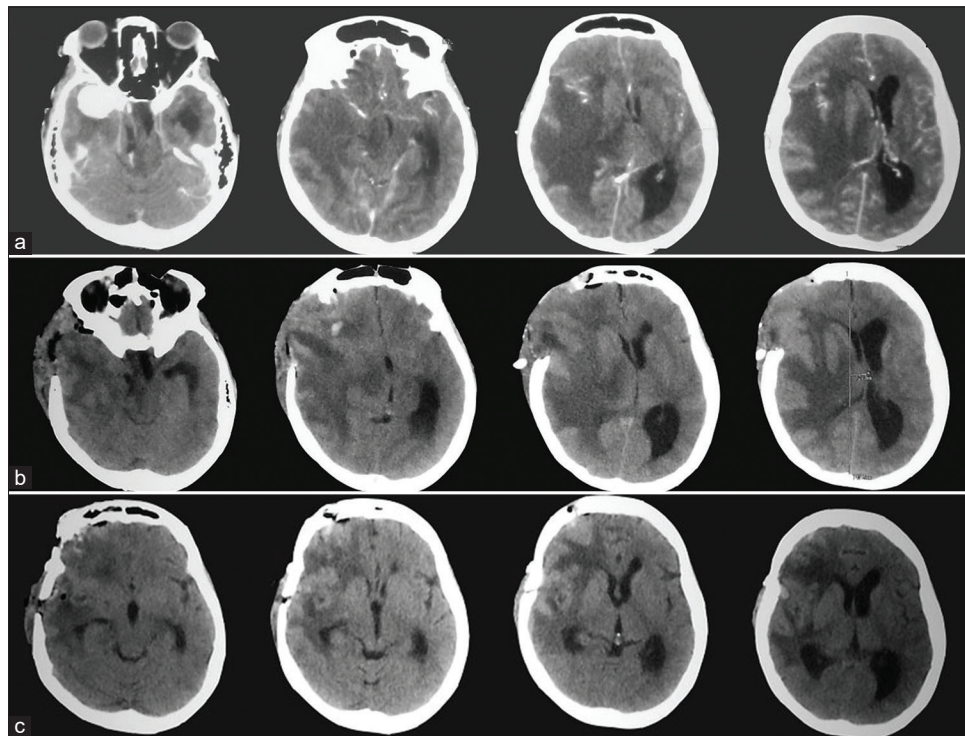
A head computed tomography scan of a 42-year-old female diagnosed with right medial sphenoid meningioma suffering of consciousness decreases for 10 days before admission. (a) Predecompressive craniectomy computed tomography scan showed a homogenous contrast-enhanced lesion in the right temporal fossa, severe brain edema was also shown in the right hemisphere with midline shifting more than 5 mm and hydrocephalus. (b) Postdecompressive craniectomy, hydrocephalus and brain edema were still observed. (c) Head computed tomography scan after tumor resection surgery in 2 days after decompressive craniectomy, several improvements were shown, brain edema and hydrocephalus were resolved
